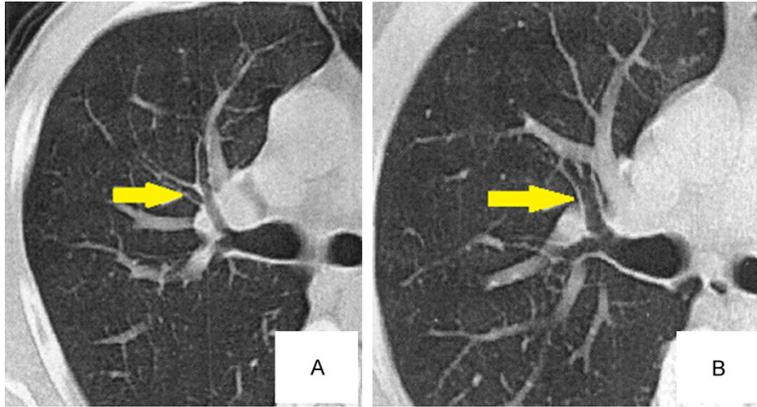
A: CT image of a child with asthma (male, 3 years old) shows that he has bronchial stenosis. B: CT image of a healthy child (female, 4 years old) with normal results.
